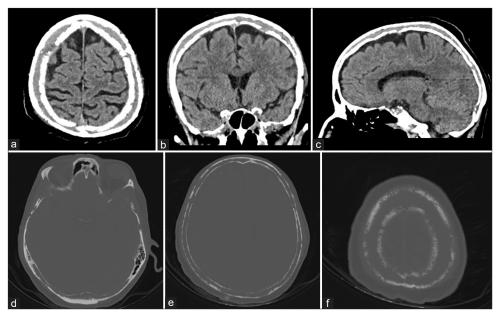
Non-contrast head computed tomography (CT) scan. (a) Axial slice showing the destruction of the diploic space (permeating growth pattern) of frontal and both parietal bones; (b) coronal slice, infiltration of the diploic space; (c) sagittal slice, the extent of tumor from the frontal to the occipital bone can be seen; and (d-f) CT scan bone window, axial slices at various levels showing diploic space destruction with mostly preserved internal and external table.
